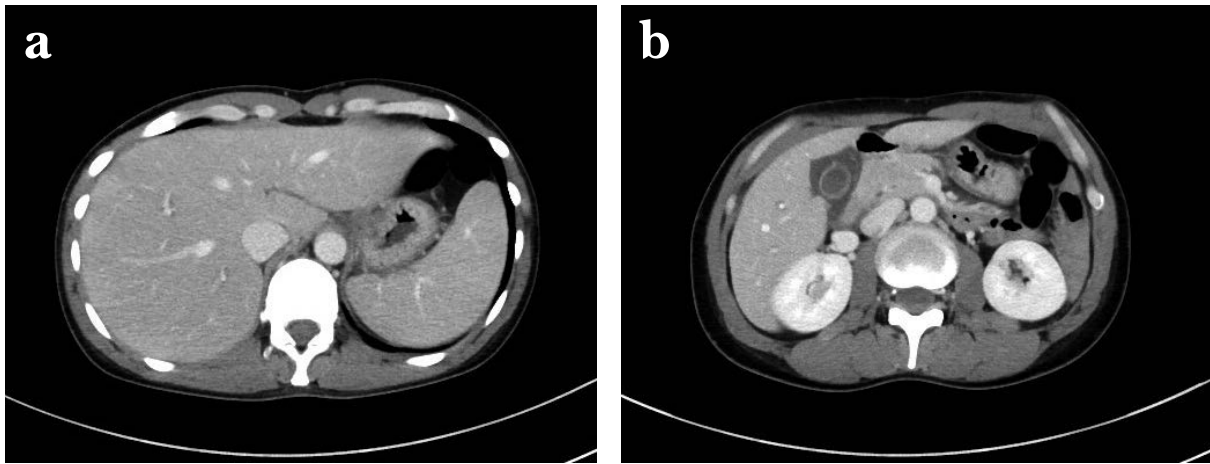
Abdominal computed tomography on admission revealed hepatosplenomegaly and a periportal collar sign.
